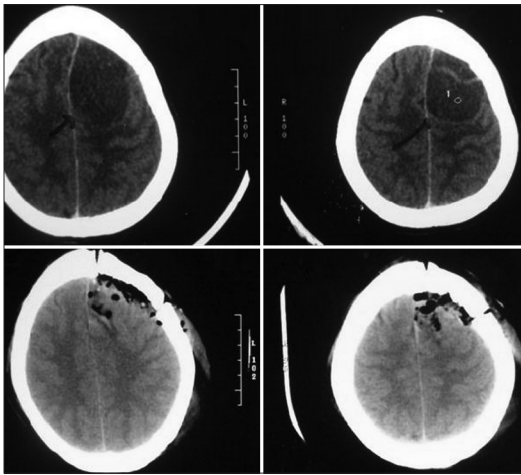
Initial computed tomography scan demonstrating pre and post operative left para-sagittal meningioma 8 years back
